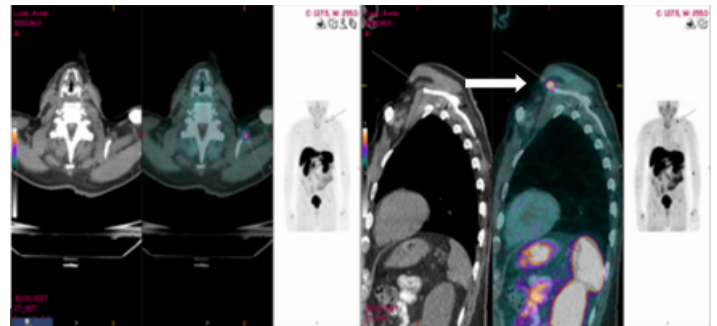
⁶⁸Gallium DOTANOC PET/CT demonstrating a small soft tissue nodule with pathologic uptake situated adjacent to the superoanterior aspect of the coracoid process (arrow).
